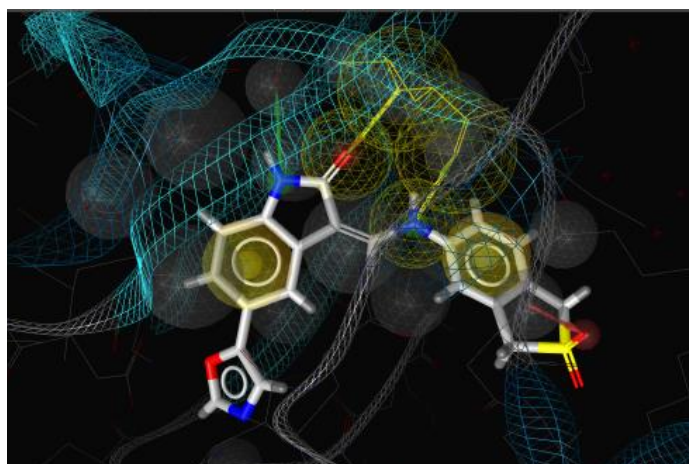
3D-Chemical feature interaction pharmacophore model automatically derived using LigandScout Advanced 4.0 using cyclin dependent kinase 2 and a kinase inhibitor (x-ray derived complex, PDB Code: 1Ke7). Interactions displayed include yellow spheres (hydrophobic), red arrows (hydrogen bond acceptors), green arrows (hydrogen-bond donors), grey spheres (excluded volumes). Such models can be used for rapid virtual screening of compound libraries to find other molecules with similar interaction features in 3D-space.
